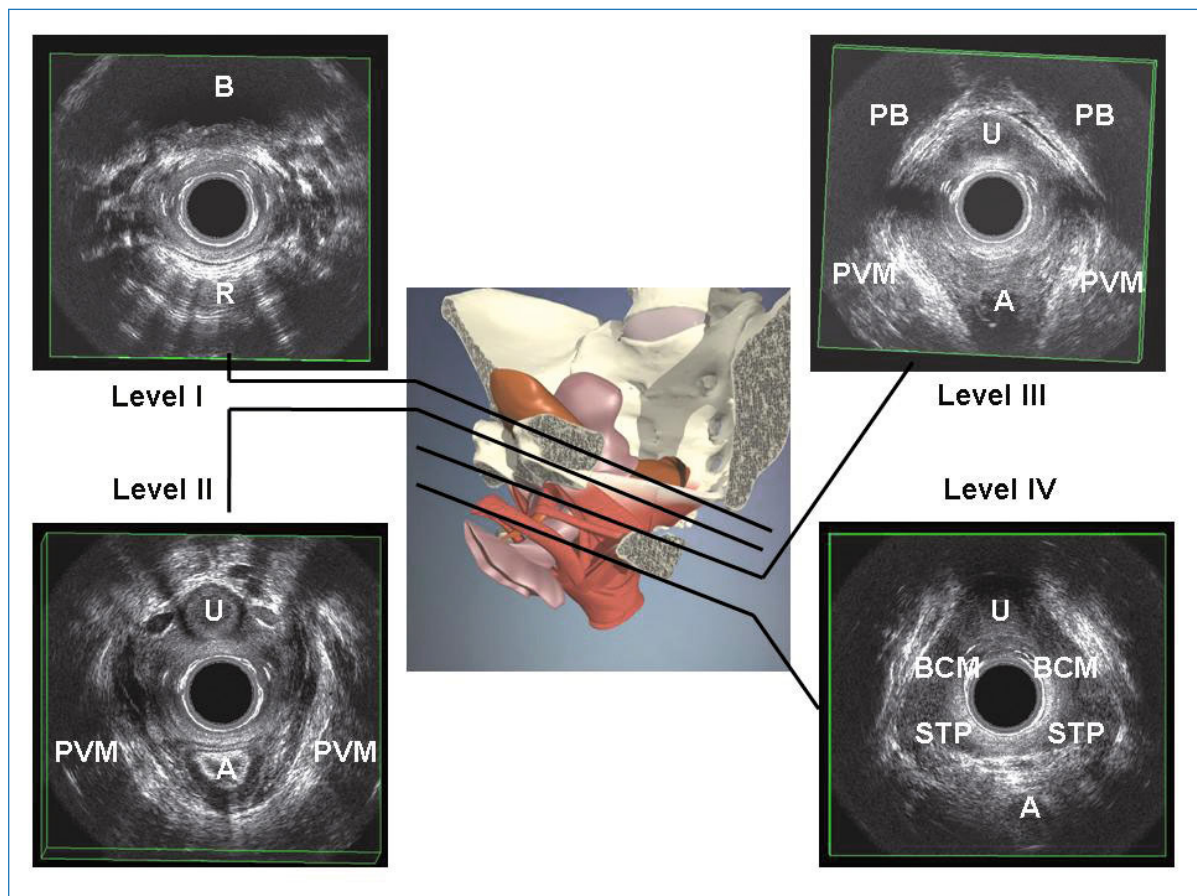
Four standard levels of assessment of the female pelvic floor with endovaginal ultrasound (2050 transducer, B-K Medical). Right side of the image is left side of the patient. A, anal canal; B, bladder; BCM, bulbocavernosus muscle; PB, pubic bone; PVM, pubovisceral muscle; R, rectum; STP, superficial transverse perineal muscle; U, urethra
